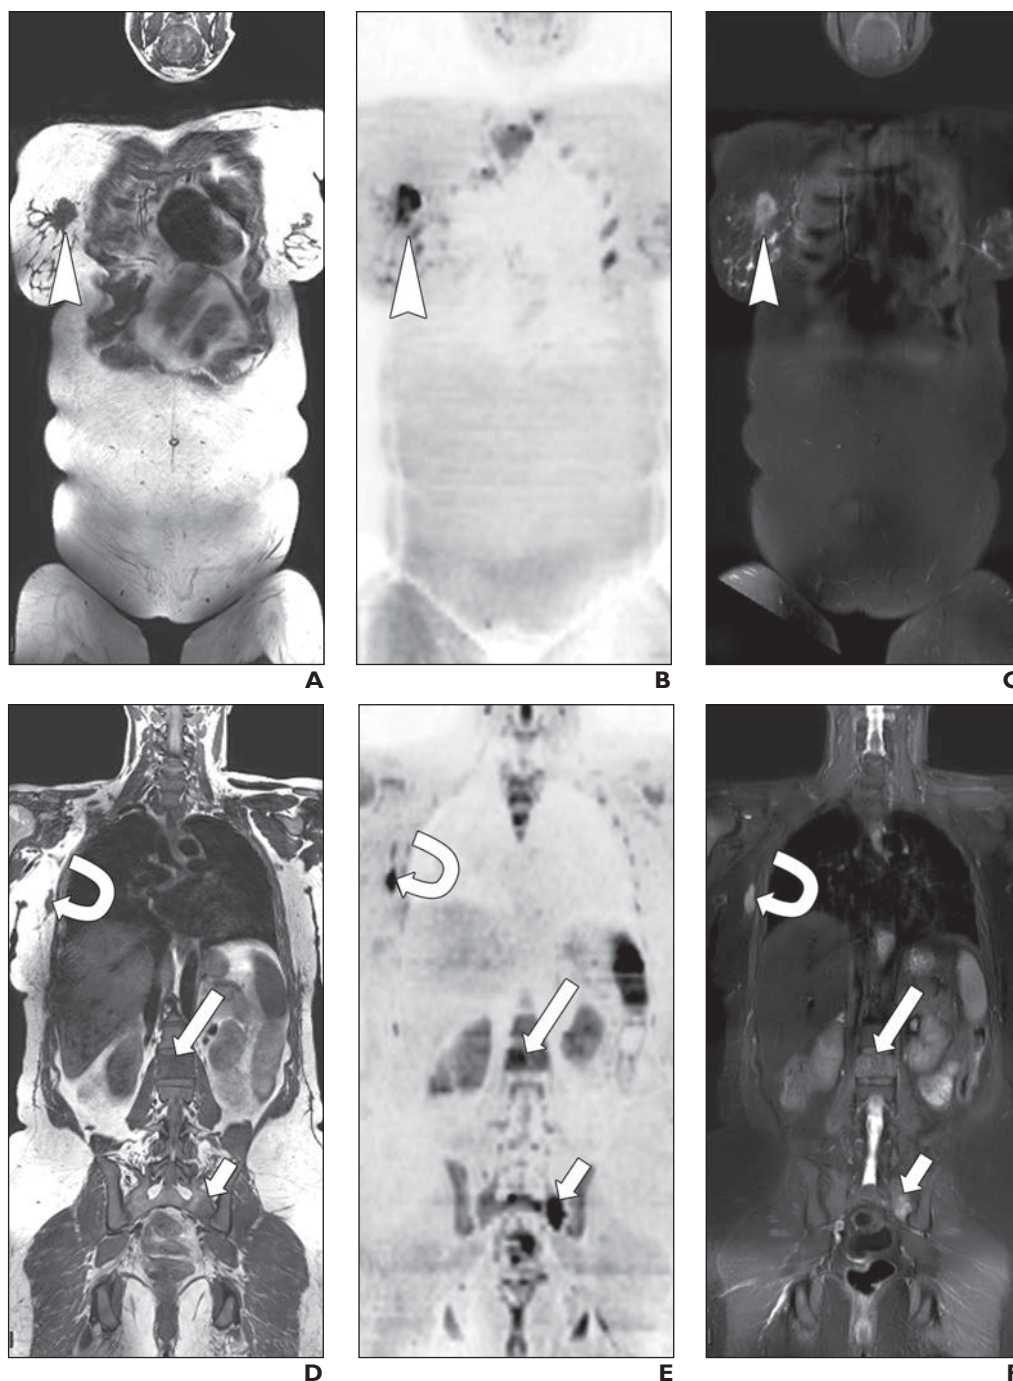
45-year-old patient with newly diagnosed breast cancer who underwent whole-body MRI (WB-MRI).
